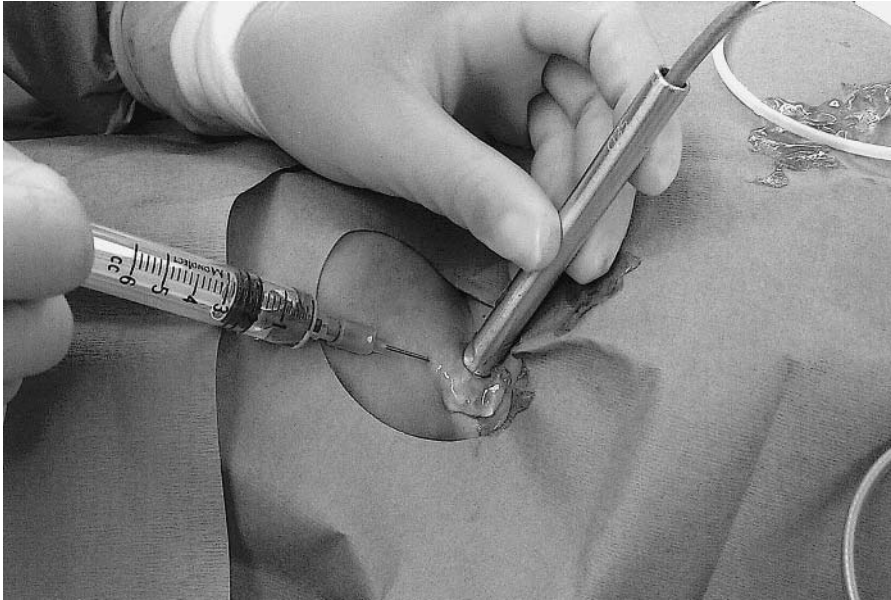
Audio Doppler-guided puncture of the internal jugular vein in an infant.
